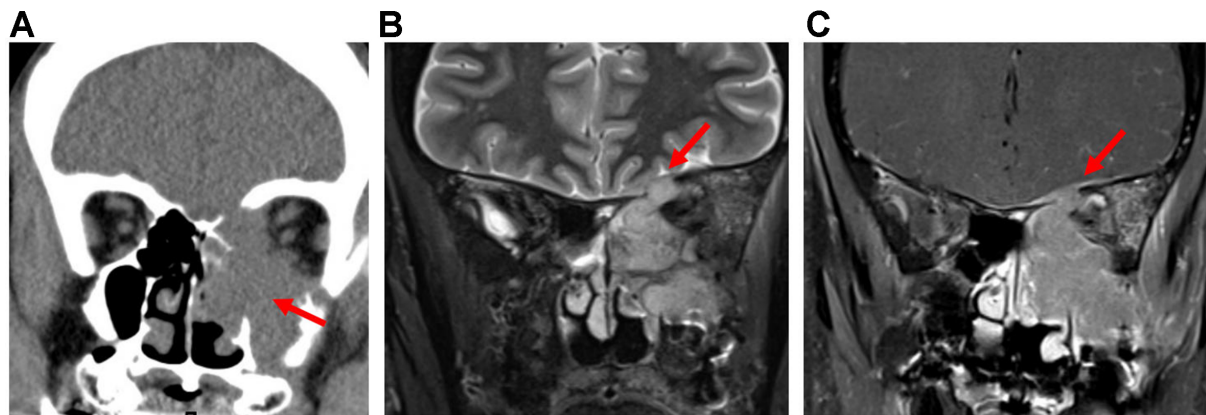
SNSCC. (A) Coronal CT image of the sinonasal cavity shows a destructive soft-tissue mass centered in the left maxillary antrum with erosion of the sinus wall, nasal cavity, ethmoid complex, orbit, and anterior skull base (arrow); (B) Coronal T2-weighted MRI demonstrates intermediate signal intensity of the tumor and loss of the hypointense zone, indicating dural invasion (arrow); (C) Coronal post-contrast T1-weighted MRI shows nodular tumor extension through the anterior skull base defect with hyperenhancing thickening of the overlying dura (arrow). SNSCC: Sinonasal squamous cell carcinoma; CT: computed tomography; MRI: magnetic resonance imaging.
